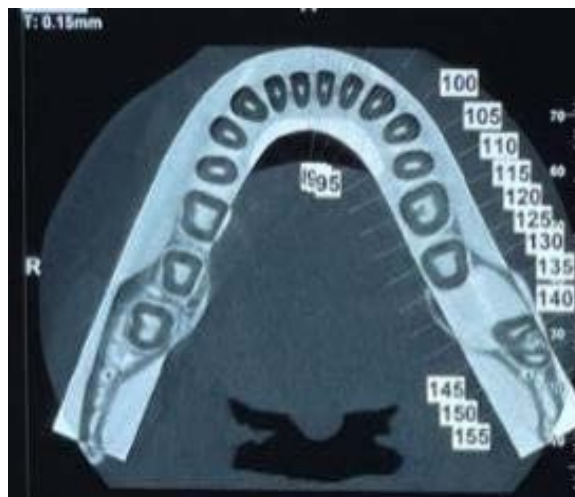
Reference panoramic reconstruction (CBCT) showing progressive bucco-lingual extension.
